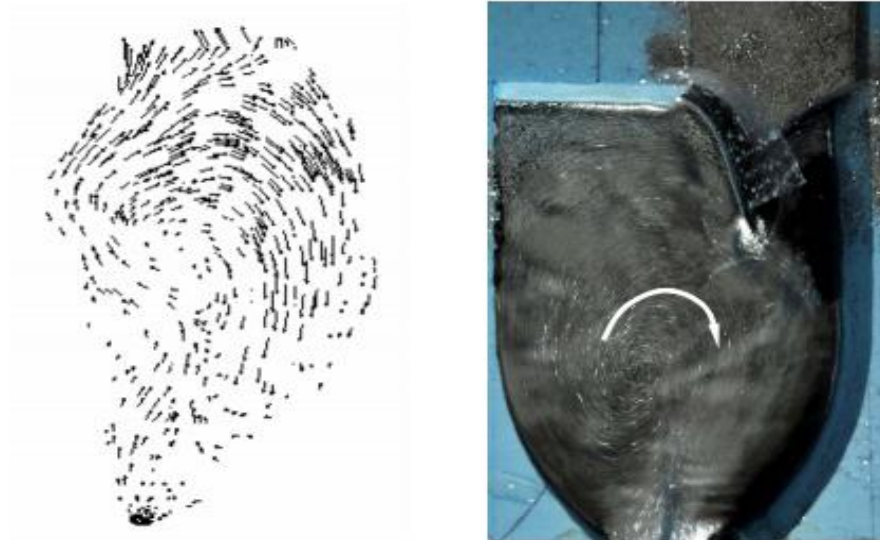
Comparison of the result from MRI scans and modeling experiment on the vortex formation in left ventricle
